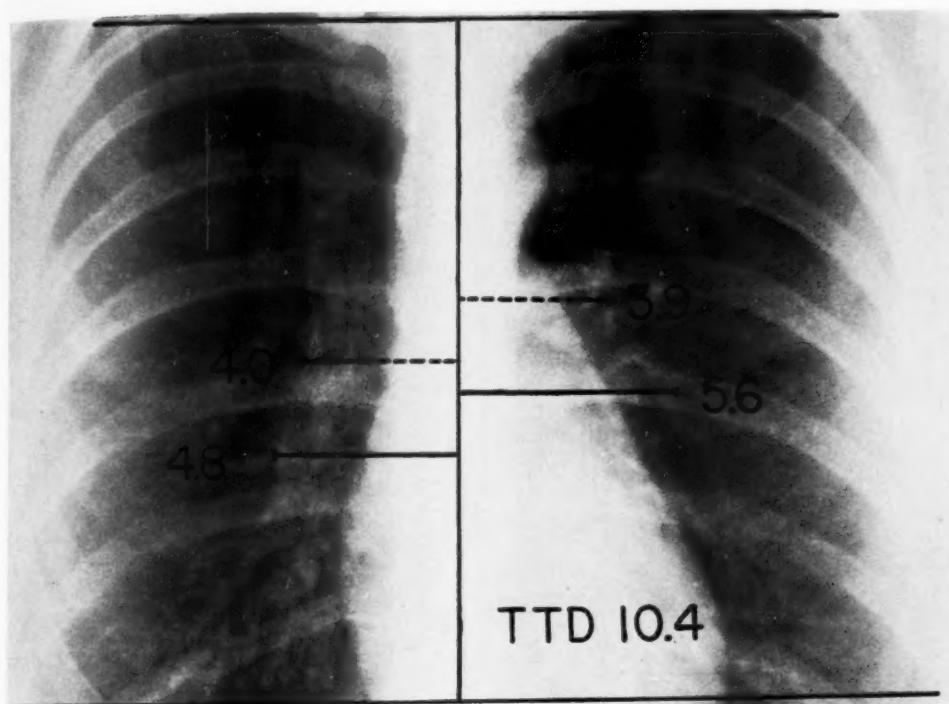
Roentgenogram of the chest showing method utilized in measuring hilar shadows. The dotted lines represent the least hilar measurements, the solid lines the greatest hilar measurements.
